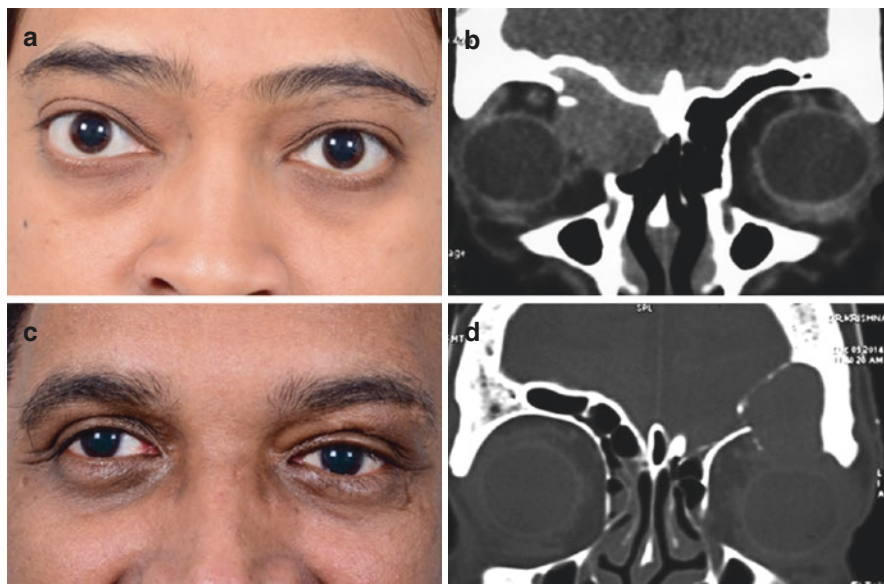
Orbital mucocele. (a) A 32-year-old female with right proptosis. (b) Coronal CT orbit reveals an irregular homogenous lesion in the superomedial orbit with opacification of both ethmoid and frontal sinuses. (c) A 45-year-old man with left hypoglobus. (d) Coronal CT orbit shows left superior mass lesion with complete opacification of the left frontal sinus
